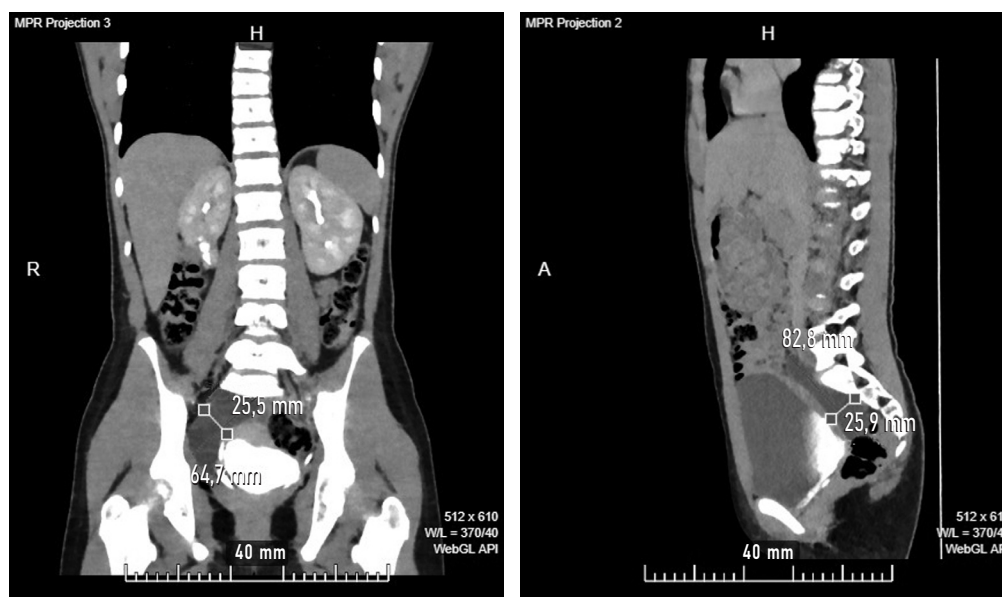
Computed tomography urography (frontal and sagittal section), delayed phase. A cystic formation is visualized (dimensions are indicated), located along the lower third of the right ureter, which does not accumulate contrast
